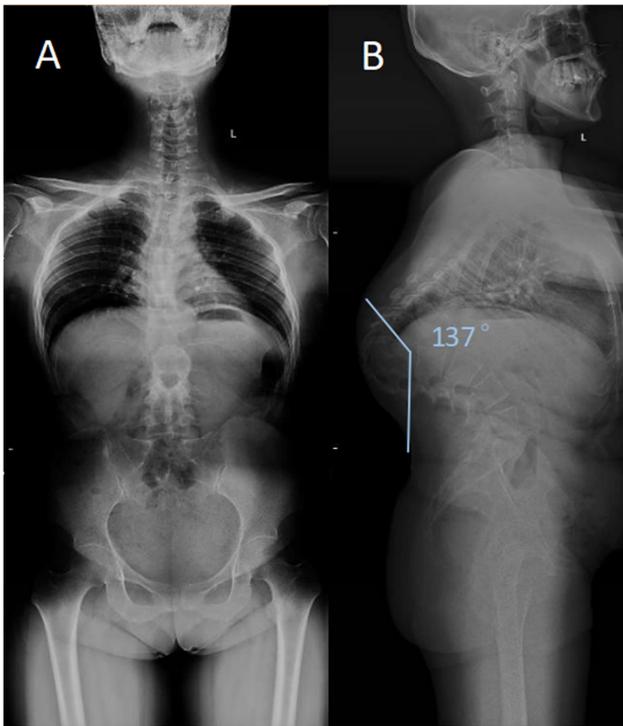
Preoperative X-ray: A full-length coronal X-ray of the spine; B full-length sagittal X-ray of the spine, with a local kyphotic angle of 137°.
